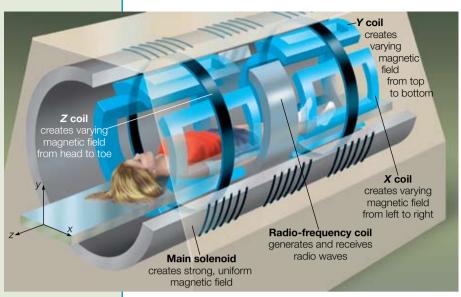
MRI apparatus: the main solenoid and the gradient coils: the main solenoid produces the strong magnetic field used to align the nuclei of the atoms while the gradient coils augment this main magnetic field. which is essential for locating the returning radio signals
